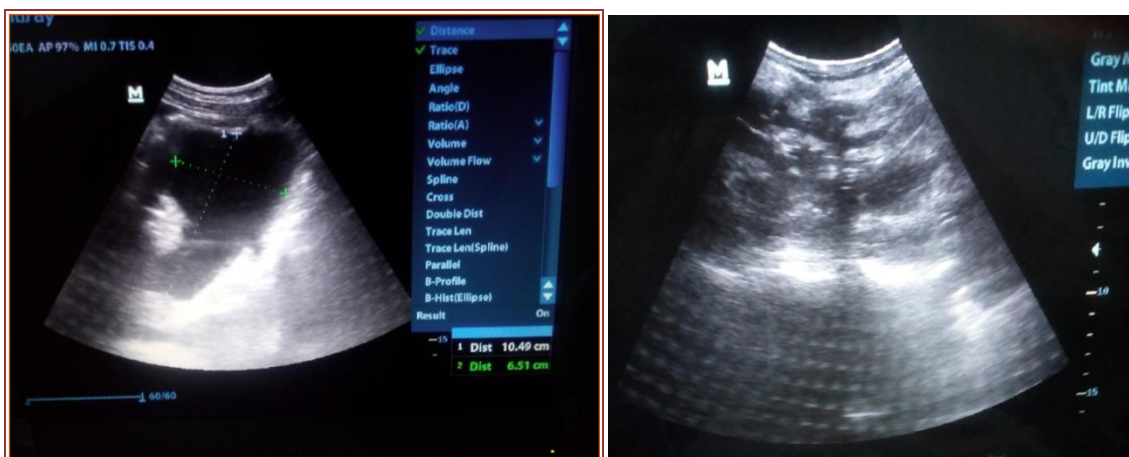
Ultrasound image demonstrating necrotic collection before and after PCD.
